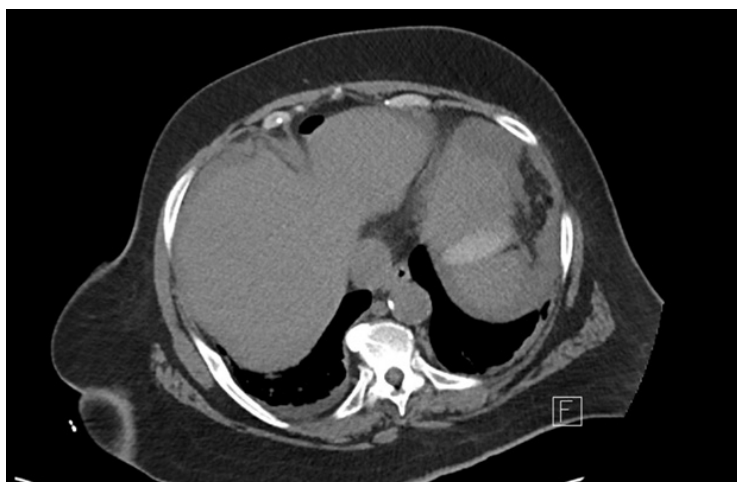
Non-contrast CT of abdomen/pelvis showing free air under the diaphragm.
